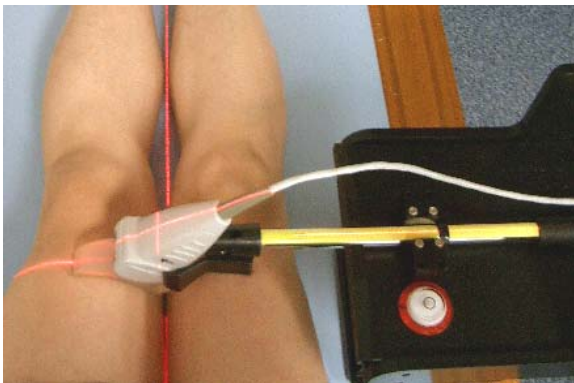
Hand-free ultrasound imaging for VMO cross-sectional area.
